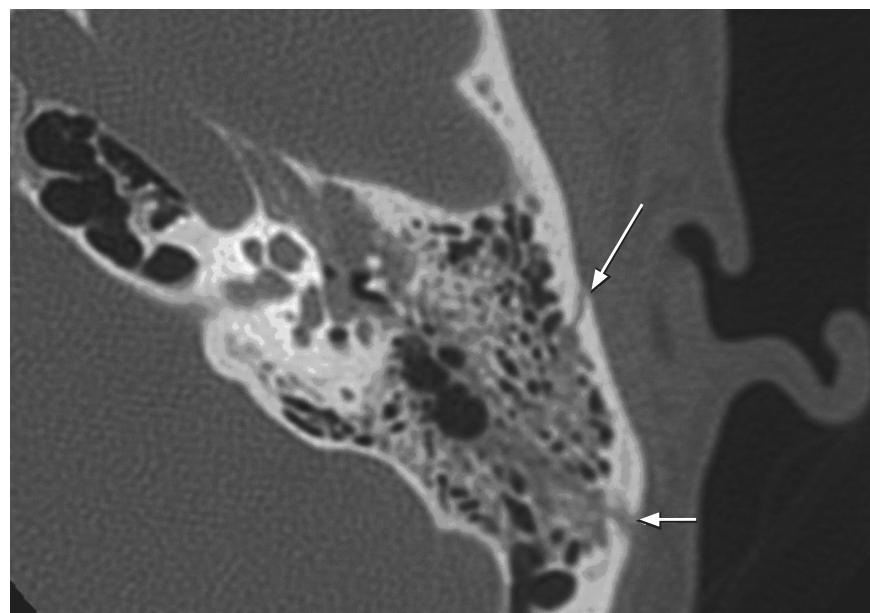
Temporal bone CT of patient showing a complex temporal bone fracture with both longitudinal (short arrow) and transverse (long arrow) components.
